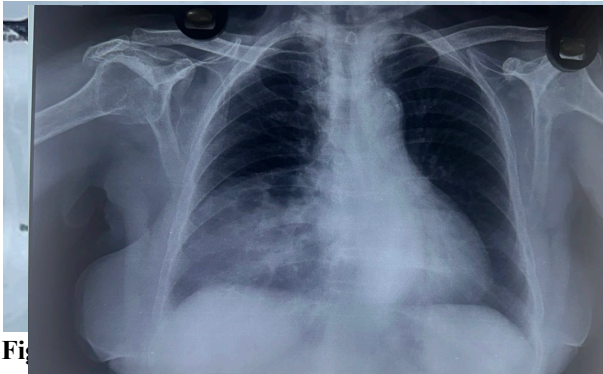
AP chest radiograph showing a large defect at midline of anterior diaphragmatic curve
